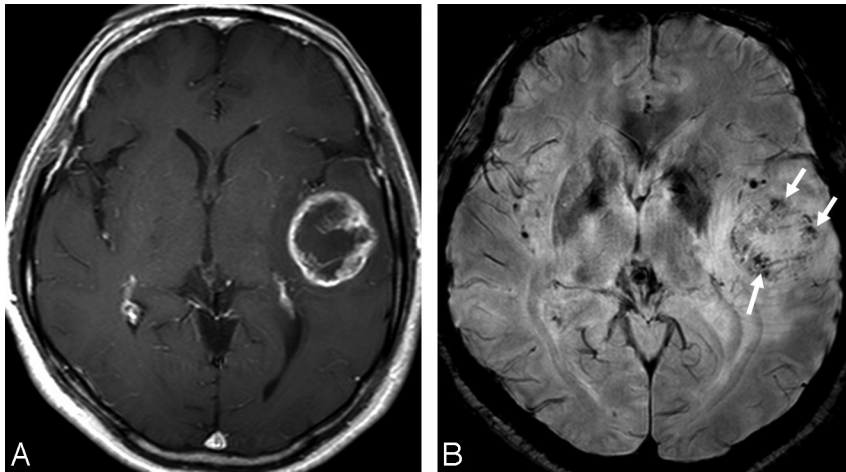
MR images of a 51-year-old woman with a left temporal GBM. *A*, The contrast-enhanced axial T1-weighted image shows a mass with peripheral rim enhancement. *B*, HR-SWI demonstrates conglomerated dotlike and fine linear ITSSs (grade 3, arrows) in the periphery of the mass.
